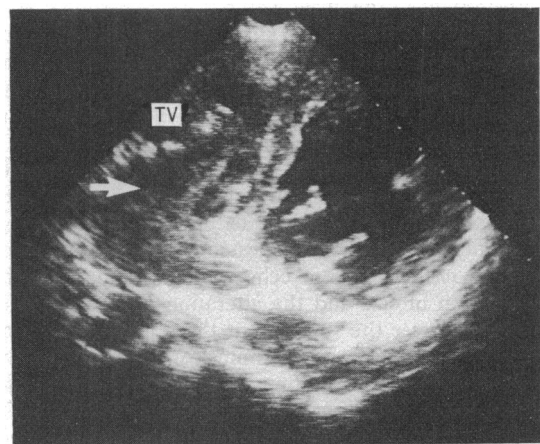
Cross sectional echocardiogram in the short axis view at left sternal border showing clot (arrow) attached to right atrial wall and protruding through tricuspid valve (TV).
